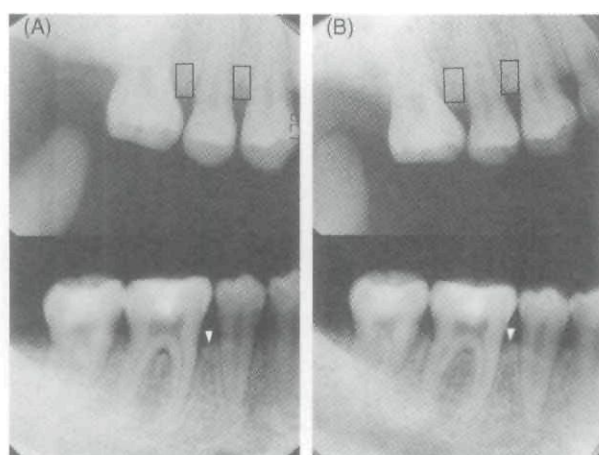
Radiographs show the remodeling of the alveolar bone from the initial visit (A) to the 2.5 yr follow-up (B). Bone density increased (square grid) and the ridge of alveolar bone became distinct and projected higher (arrow heads).
